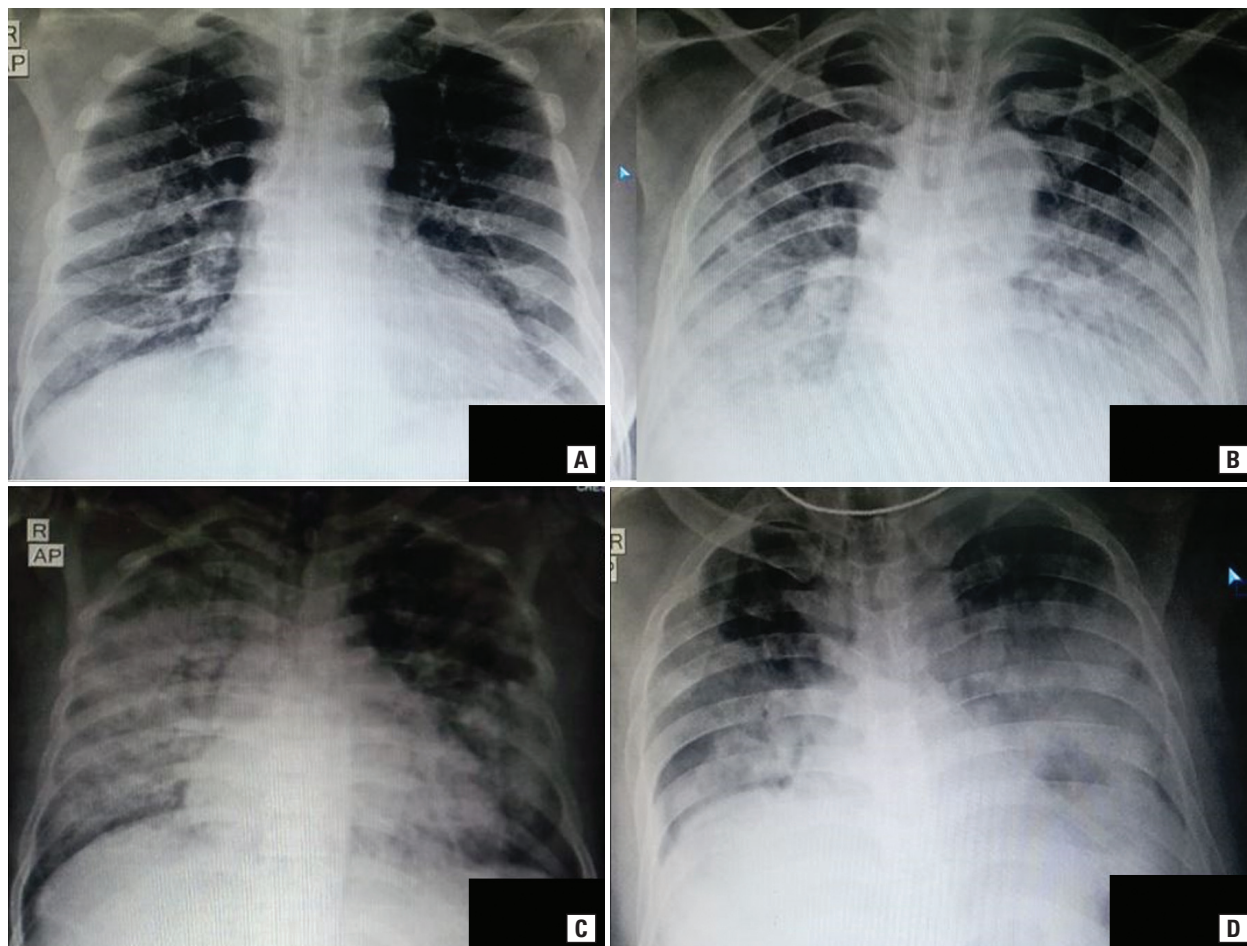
Chest radiograph showing bilateral air space opacities with increased opacities in radiograph B as compared to A, and D as compared to C
